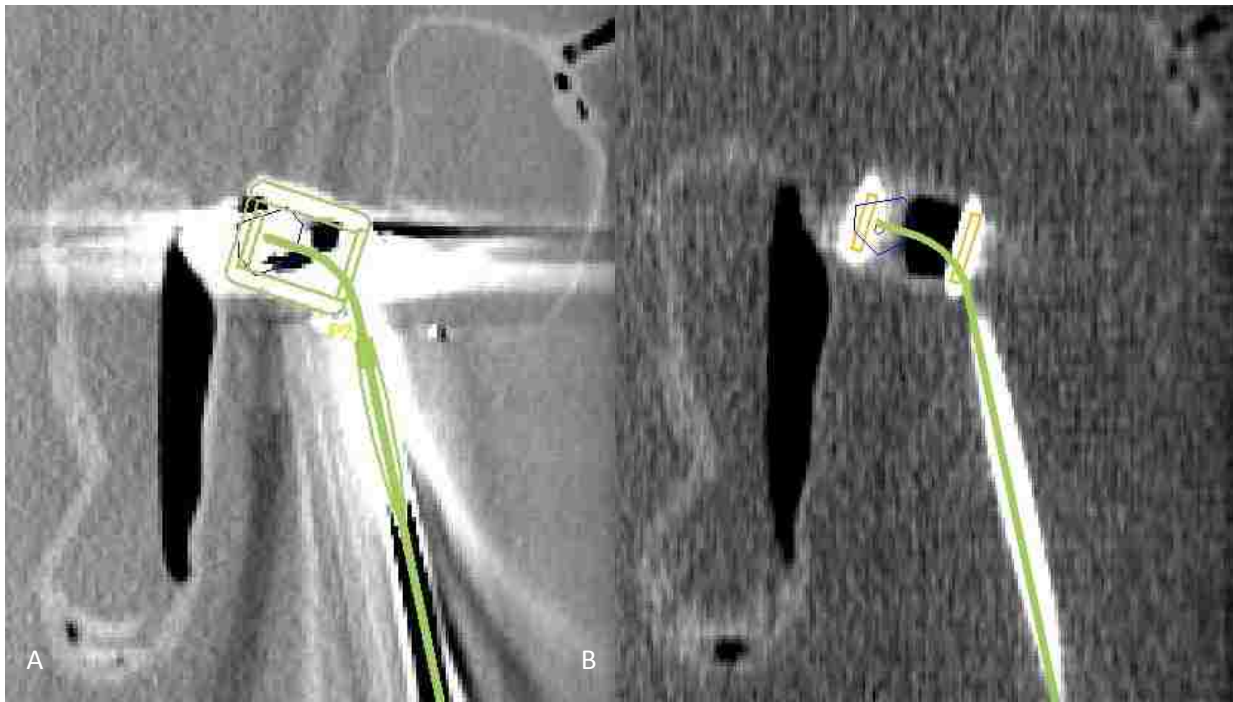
Visual example of AMp catheter reconstruction in the presence of CT metal artifact in (A) KVCT and (B) MVCT data sets.
